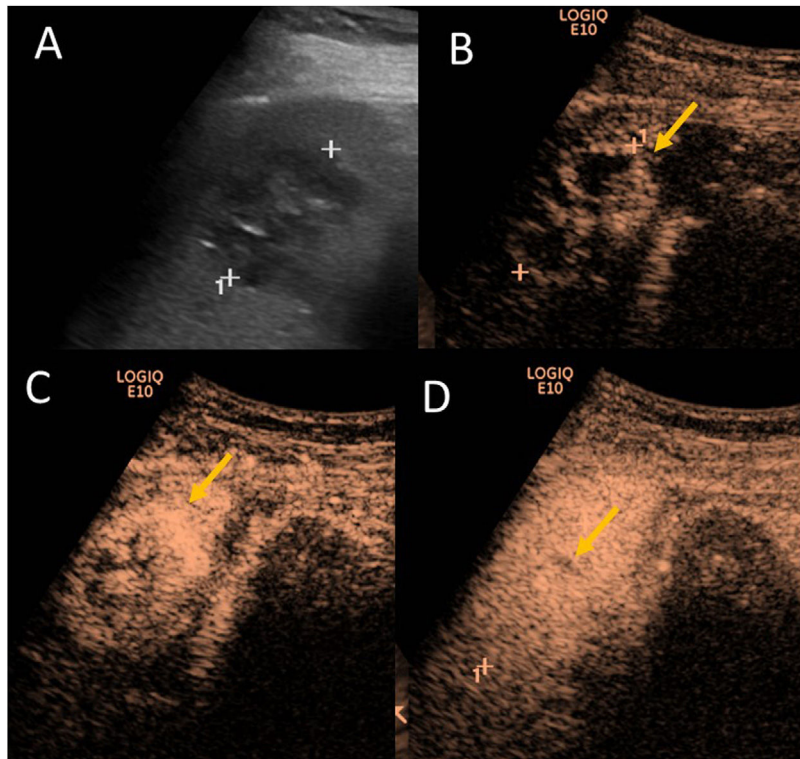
48-year-old woman attending for routine ultrasound. (A) Baseline grey scale ultrasound showing several lesions with hyper- and hypoechogenic areas within them (one of which is marked between cursors). (B–D) Contrast-enhanced ultrasound scans in arterial (12 seconds) (B), parenchymal (60seconds) (C) and late (120seconds) (D) phases, demonstrating nodular peripheral enhancement in the arterial phase, gradual centripetal uptake with complete filling of the lesion and persistent enhancement in late phases (yellow arrows). The suggested diagnosis was a haemangioma.
